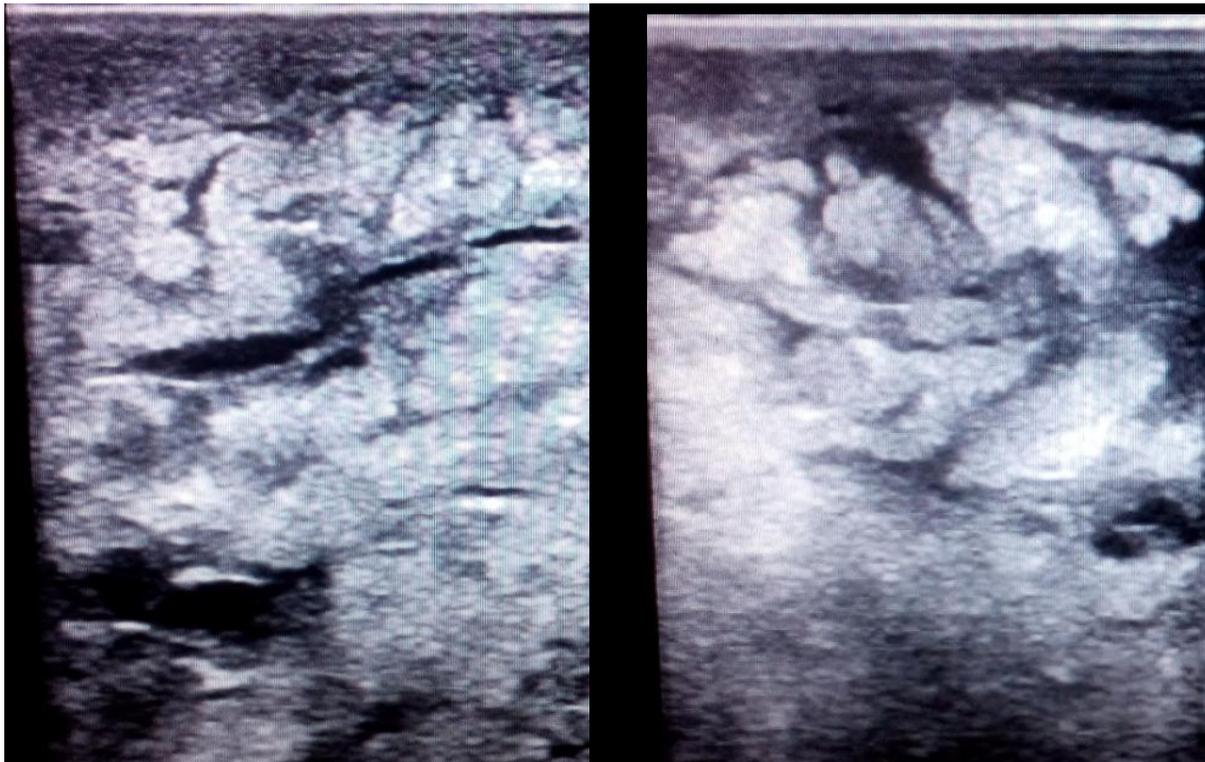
Ultrasound image of fibrosed part of the udder
